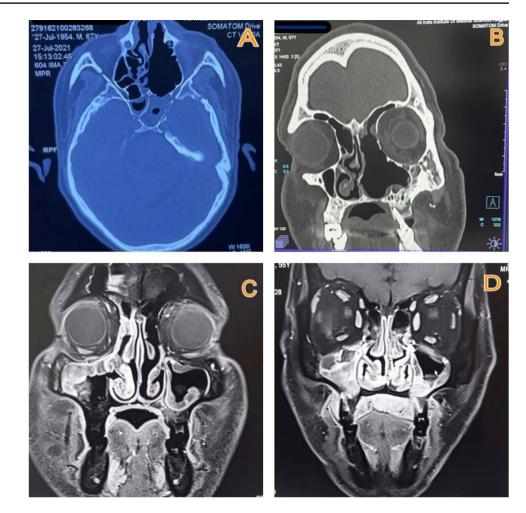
A Plain Axial CT image showing sphenoidal mucosal thickening and lateral wall erosion, B Plain Coronal CT image showing orbital collection in operated case, C, D Post contrast MR coronal image showing hyperintense signals from sinus mucosa
